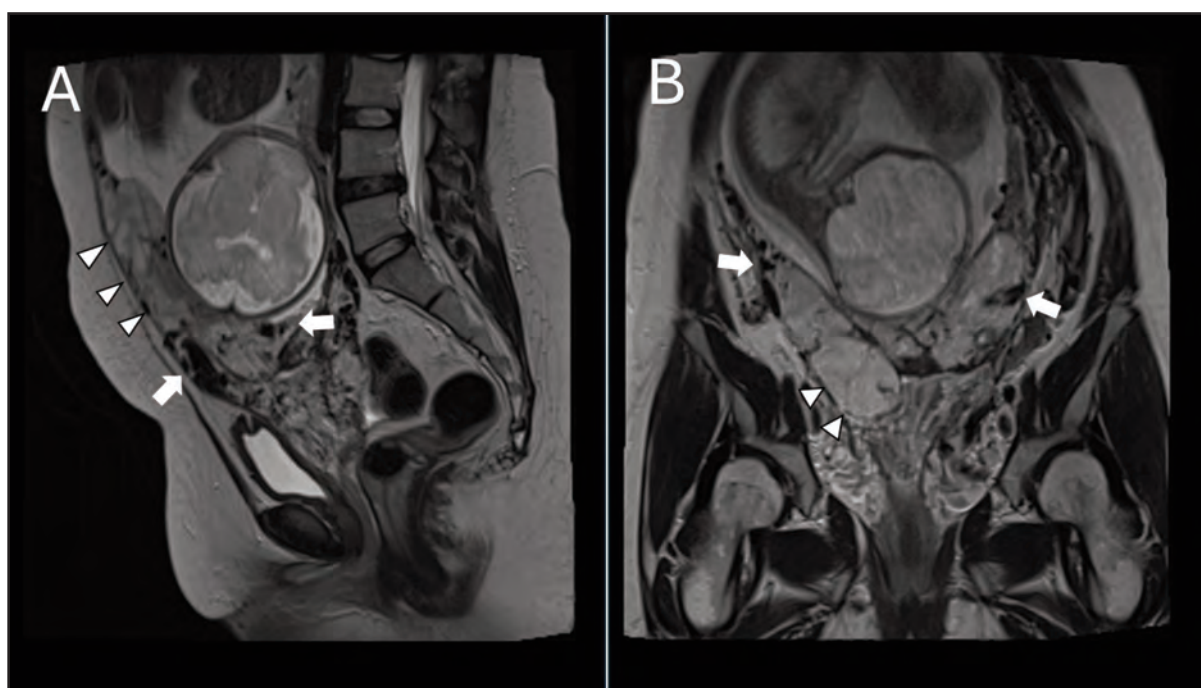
MRI T2W Sagittal (A) and Coronal view (B): Placenta previa major with abnormal intra-placental vasculature (white arrow in "A" and "B"). Thinned out myometrium with loss of normal hypointense myometrial interface between the placenta and the myometrium (white arrowheads in "A"). Placental bulge at the right lower uterine segment (white arrowheads in "B")
